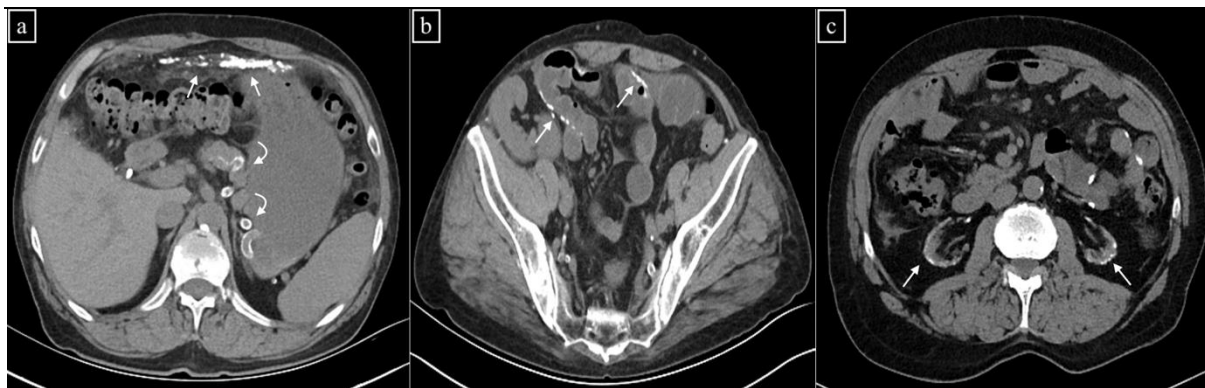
Non-contrast abdominal CT images show calcifications in blood vessels (curved arrows on a), omentum (arrows on a), intestinal mucosa (arrows on b) and atrophic renal parenchyma (arrows on c).
